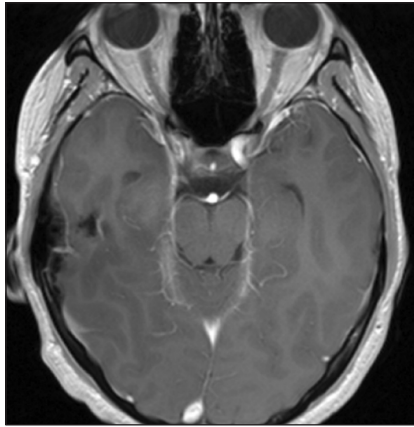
Brain MRI, T2 weighted image: no signs of focal lesions
